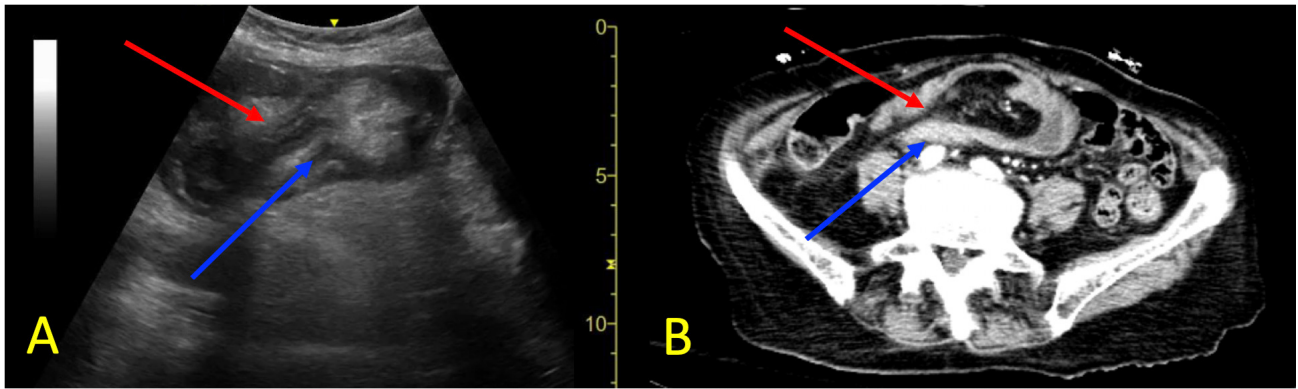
Longitudinal views of the transverse colon on point-of-care ultrasound (A) and computed tomography with contrast (B) images demonstrating a transition point with invagination. Invagination of the intussusceptum (red arrow) into the intussusciens (blue arrow) is visualized. Hypoechoic edema of the outer bowel loop (A, blue arrow) and hyperechoic, compressed telescoping bowel (A, red arrow) are noted.
